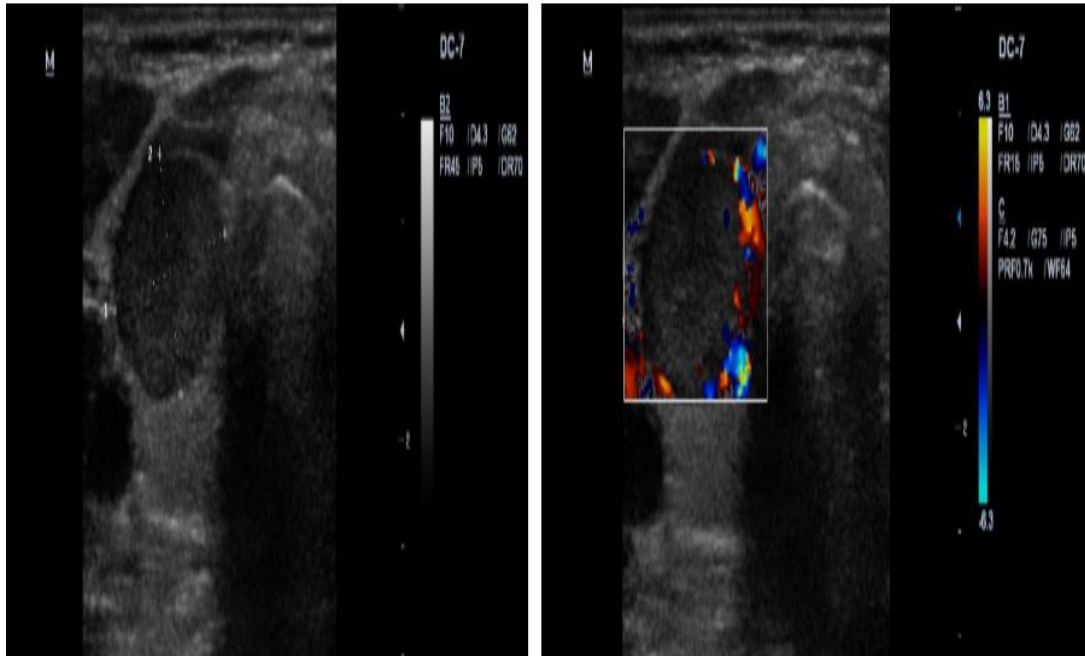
(a) Gray scale and (b) Colour Doppler images showing solid hypoechoic, tall than wide nodule with regular margins, absent halo and peripheral vascularity on Doppler, diagnosis of Malignant nodule was given ultrasound however proved to be benign colloid nodule on FNAC. (False Positive)
